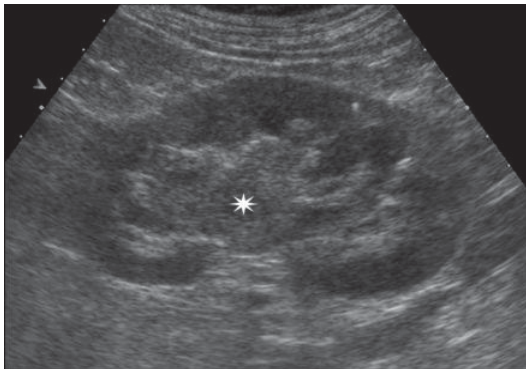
Ultrasonography. Transitional cell carcinoma. Solid centropelvic lesion (*asterisk*) extending into the mid and superior caliceal systems
